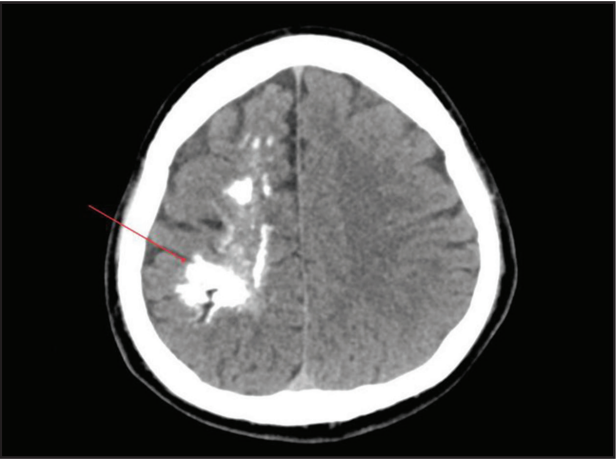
Non-contrast axial CT brain demonstrating extensive unilateral gyriform and nodular cortical-subcortical calcifications involving the right frontal and parietal lobes (red arrows), with a linear calcified component extending along the periventricular region.
